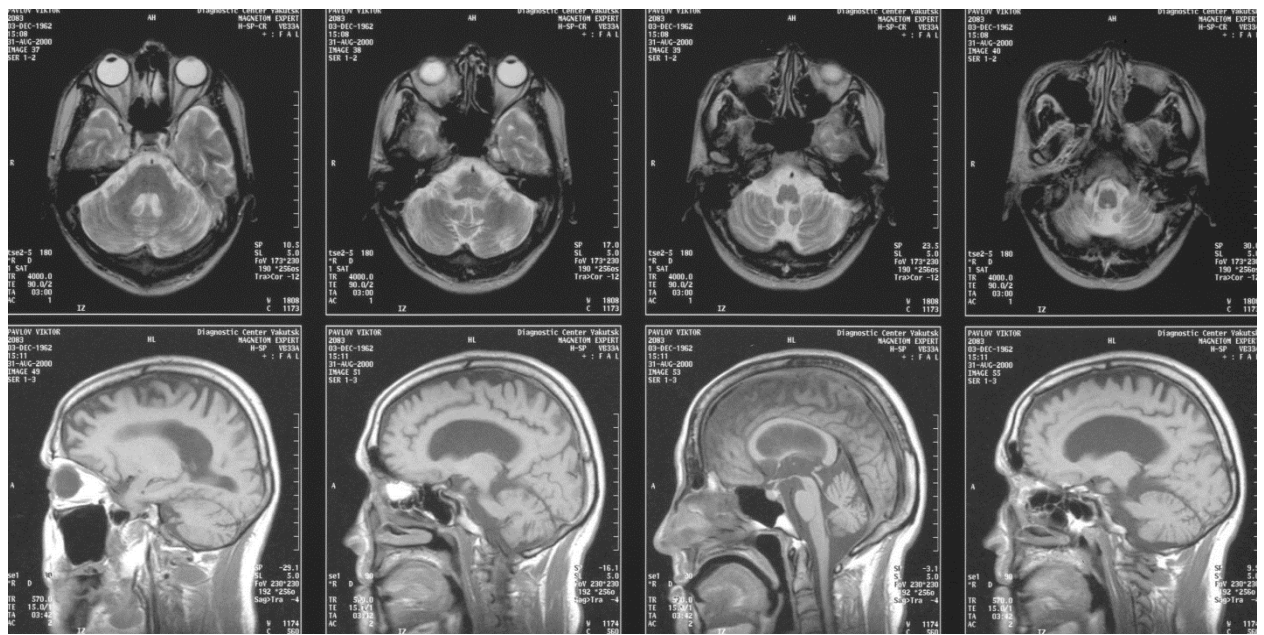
CT scan of a patient with chronic VEM. Pronounced normal pressure hydrocephalus, cortical atrophy of the brain and cerebellum (V.A. Vladimirtsev 2013)
